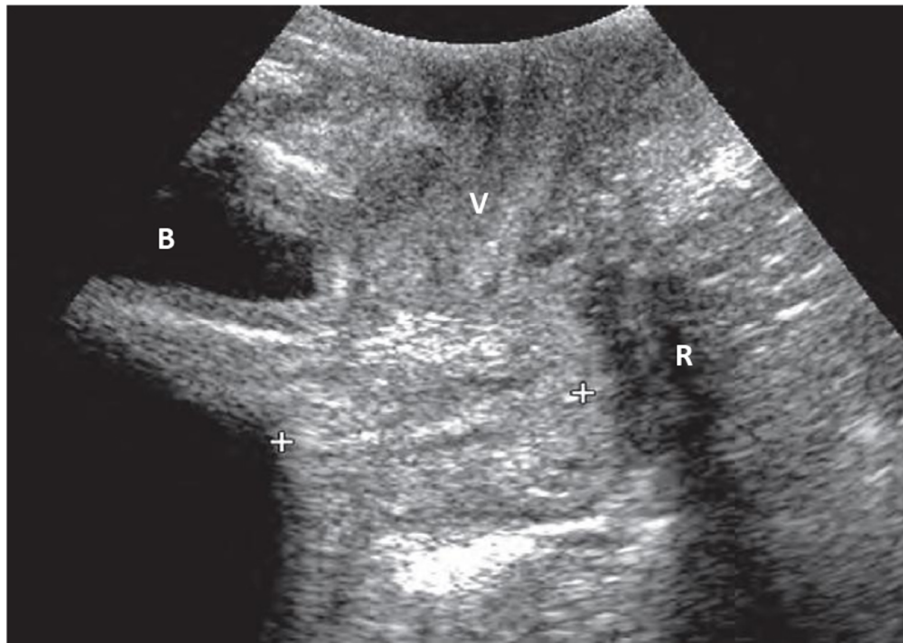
Transperineal scan of normal cervix. The cervix (calipers) is oriented horizontally, approximately perpendicular to the ultrasound beam. The vagina (V) is oriented in a nearly vertical plane. B, Bladder; R, rectum
